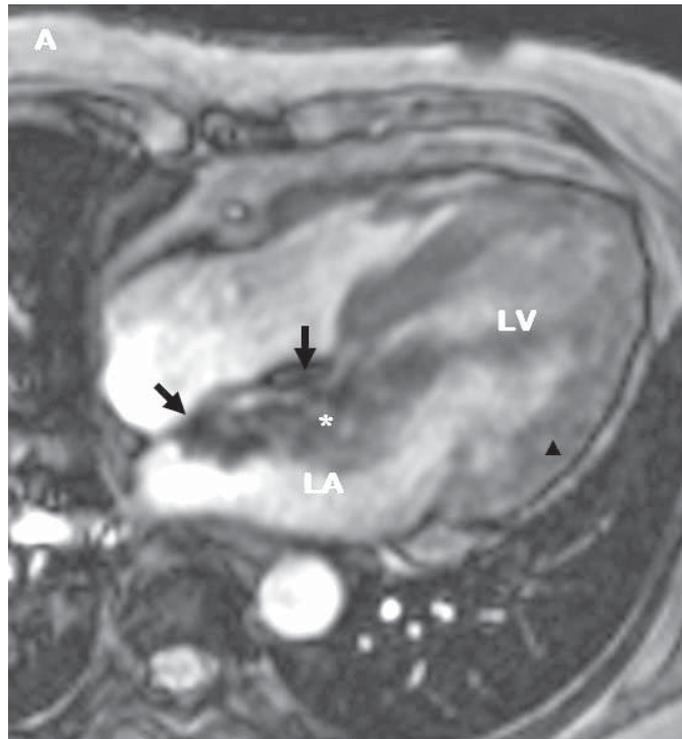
The gradient echo CINE MRI image demonstrates the left atrial mass (*) atrial myxoma with two stalks that attaches to the left side of the inter-atrial septum (black arrow). The myxoma produces heterogeneous hypointensity among the iso intensity (to myocardium) background (▲).
